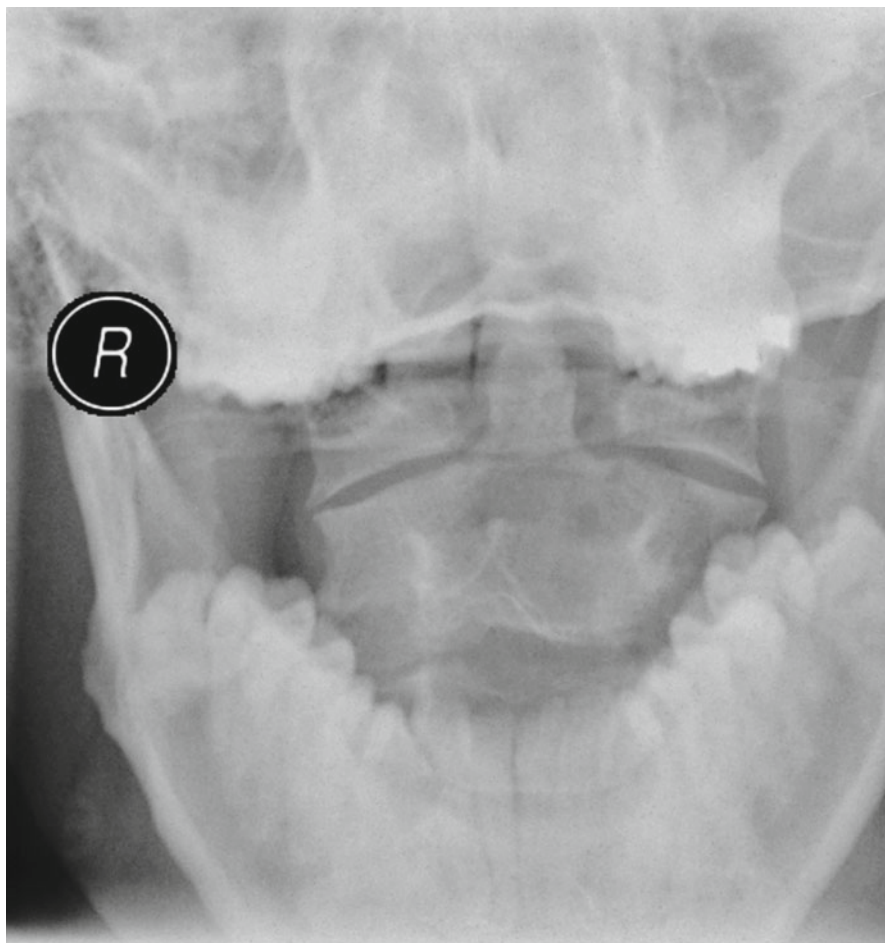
Open-mouth radiograph demonstrating an Anderson and D'Alonzo type II odontoid fracture (Courtesy of Shibu P. Krishnan, London, UK)
